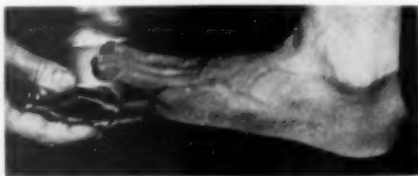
Severe scar pain at site of amputated fourth and fifth toes. Ultrasound is applied by immersion method.
